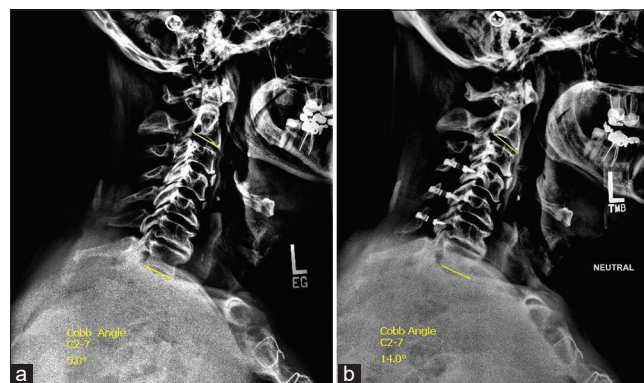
Radiographic assessment of the cervical spine in patients with cervical spondylotic myelopathy. (a) Preoperative X-rays in a 60-year-old male. (b) Postoperative X-rays in a 60-year-old male demonstrating kyphotic changes based on the C2-7 Cobb angle
